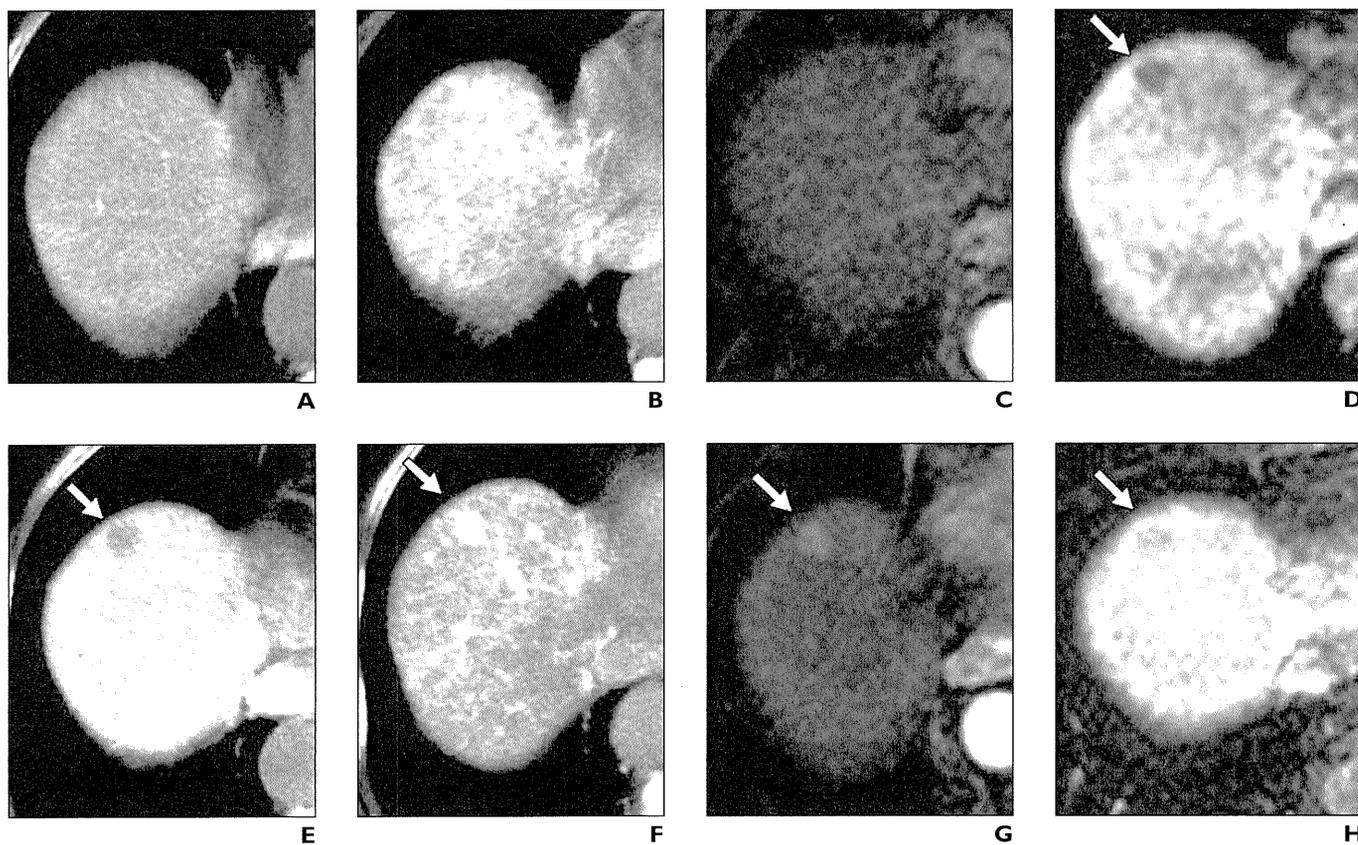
75-year-old woman with hepatitis C-related cirrhosis. A, CT arterial portogram at beginning of follow-up shows no nodules. B, CT hepatic arteriogram at beginning of follow-up shows no nodules. C, Arterial phase of gadoxetate disodium-enhanced MR images at beginning of follow-up shows no nodules. D, Hepatobiliary phase gadoxetate disodium-enhanced MR image at beginning of follow-up shows markedly hypointense nodule (arrow). E, CT arterial portogram image 9 months after A–D shows hypoattenuating nodule (arrow). F, CT hepatic arteriogram 9 months after A–D shows hyperattenuating foci in nodule (arrow). G, Arterial phase gadoxetate disodium-enhanced MR image 9 months after A–D shows hyperattenuating nodule (arrow). H, Hepatobiliary phase gadoxetate disodium-enhanced MR image 9 months after A–D shows slightly hypointense nodule (arrow).
